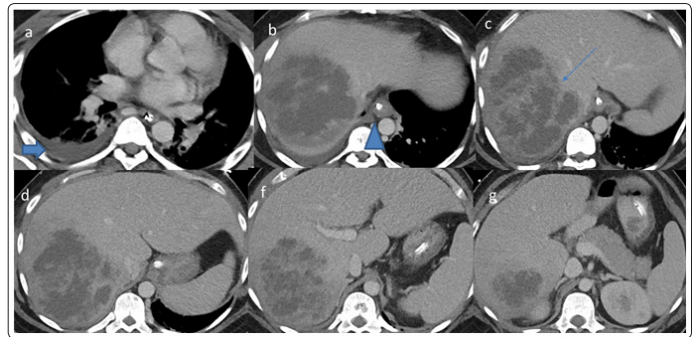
CT scan with intravenous contrast done after US reveals thin-walled abscess, internal necrotic debris (thin arrow in image c) in right lobe of liver. Right pleural effusion (thick arrow in image a), Feeding tube seen (Triangle in image b).
